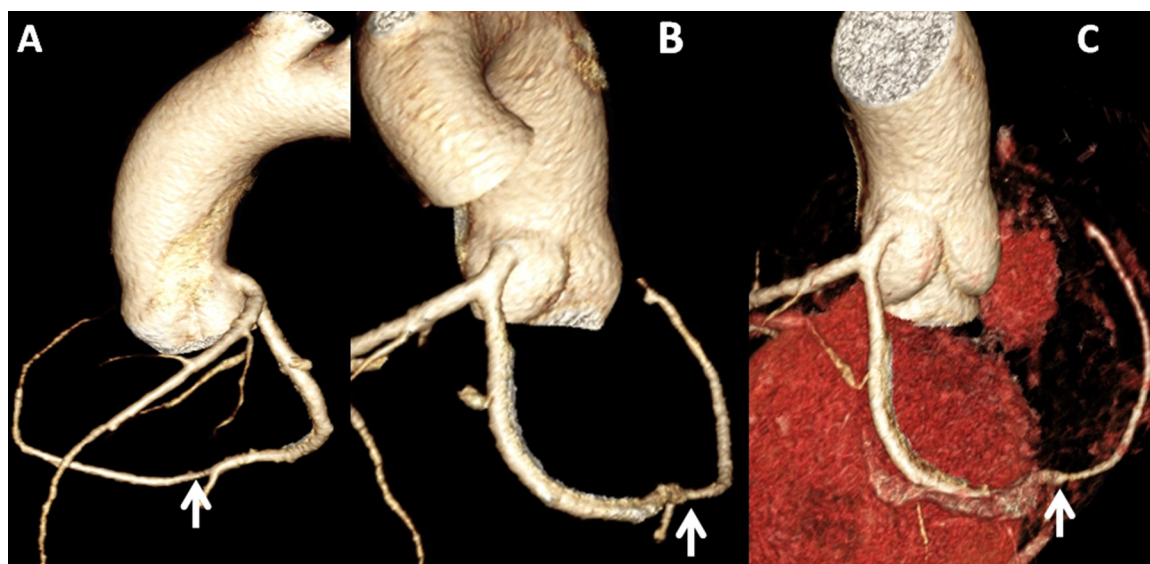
Coronary CT projections in different views (subtracted and un-subtracted images) showing ostial atresia of RCA and retrograde filling of RCA from left circumflex artery through coronary cascade.
